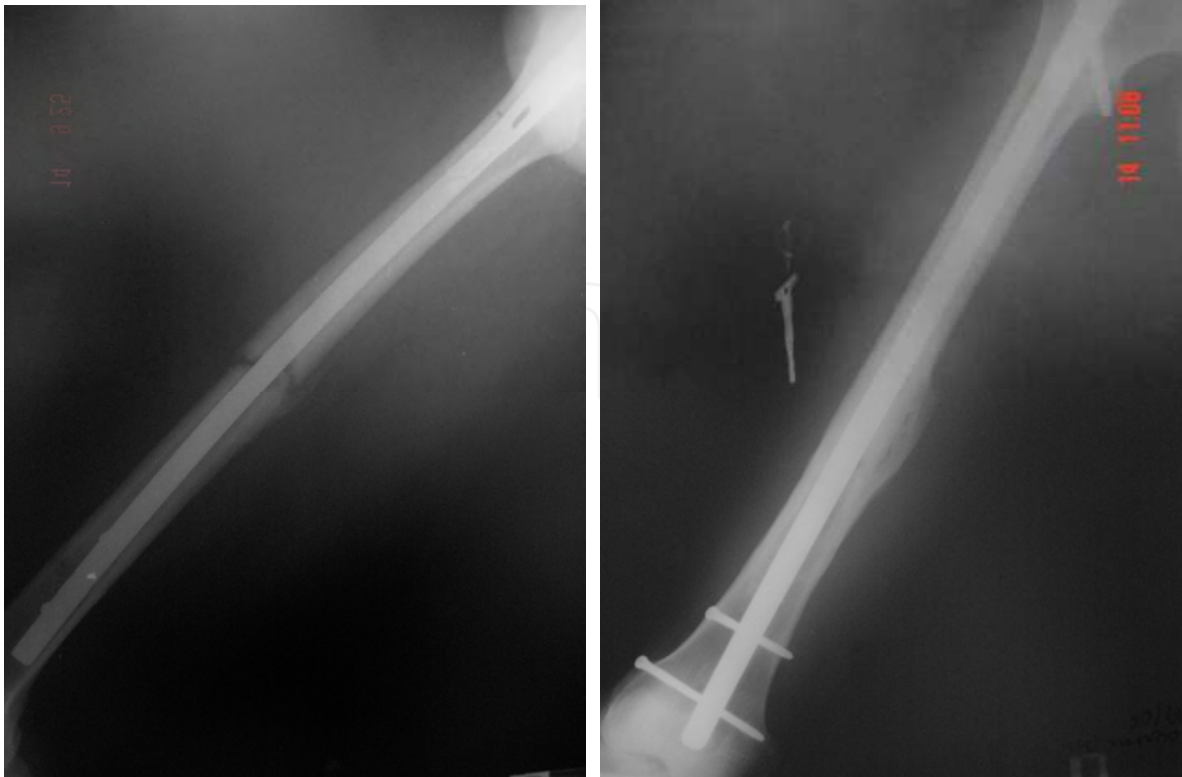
Radiograph of a diaphyseal femoral nonunion (left), in a patient using a blocked intramedullary nail, treated with the substitution of the nail for a longer one with a larger caliber, resulting in consolidation (right).
